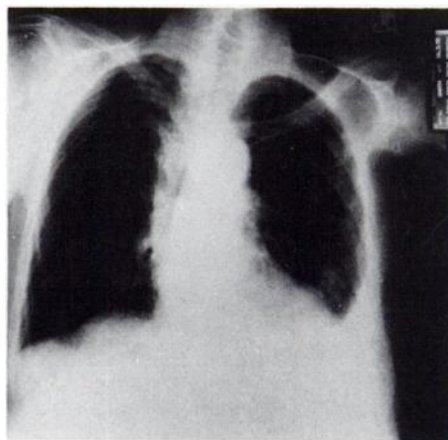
Chest x-ray shows raised segment of right hemidiaphragm and left basal carcinoma.
